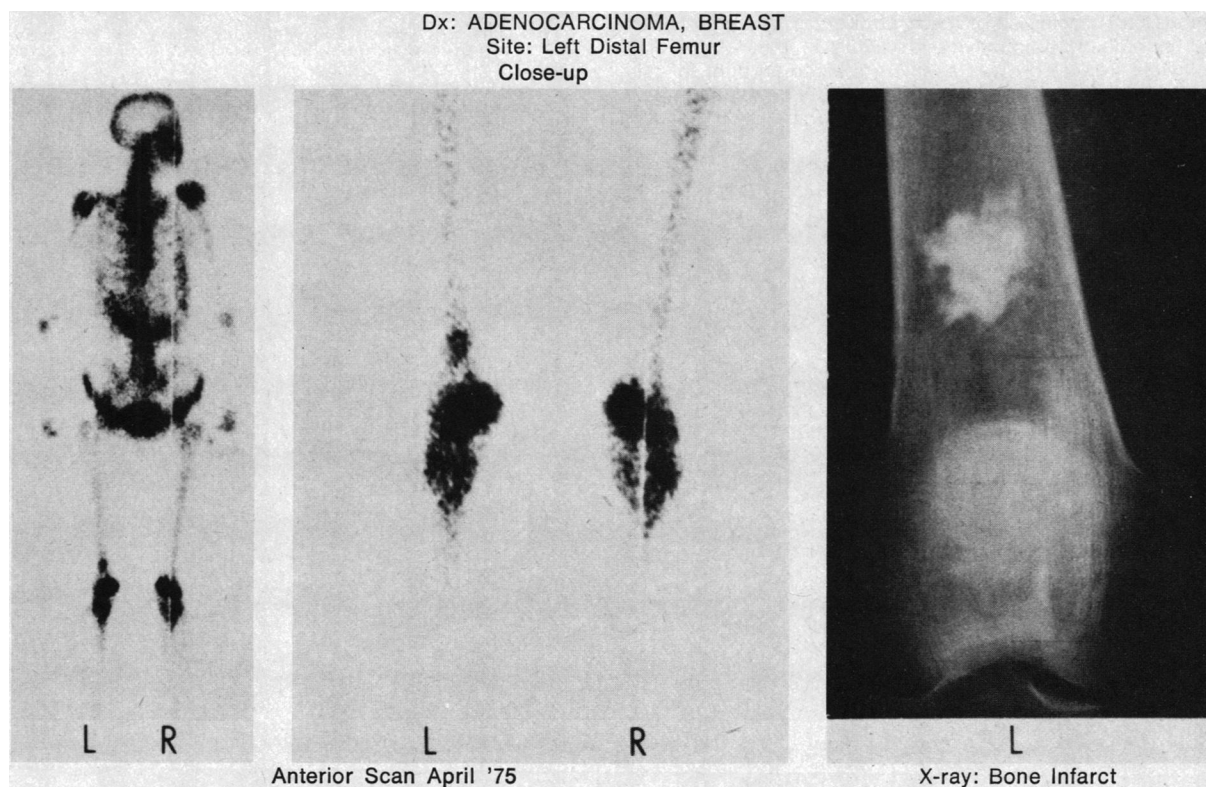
Bone scan of a 67-year-old woman with adenocarcinoma of the breast. A single focus of increased radioactivity is seen in the left distal femur. The radiograph showed a bone infarct.
